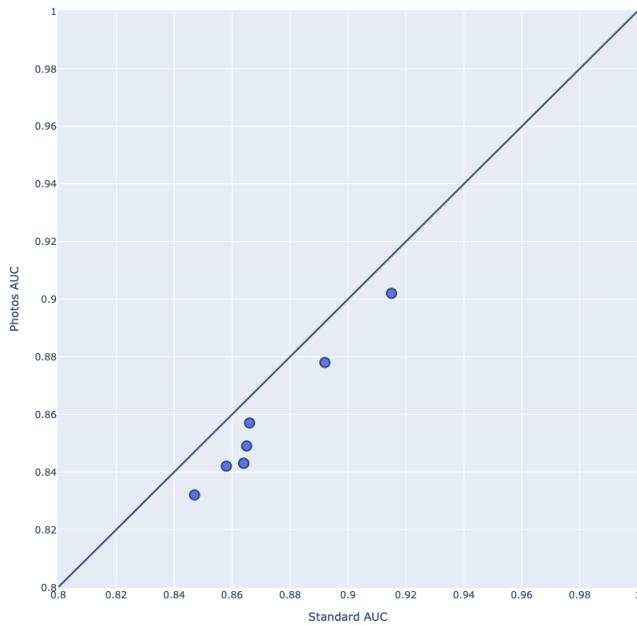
Comparison of the average AUC of 8 individual models on photos of chest X-rays compared to on standard images
